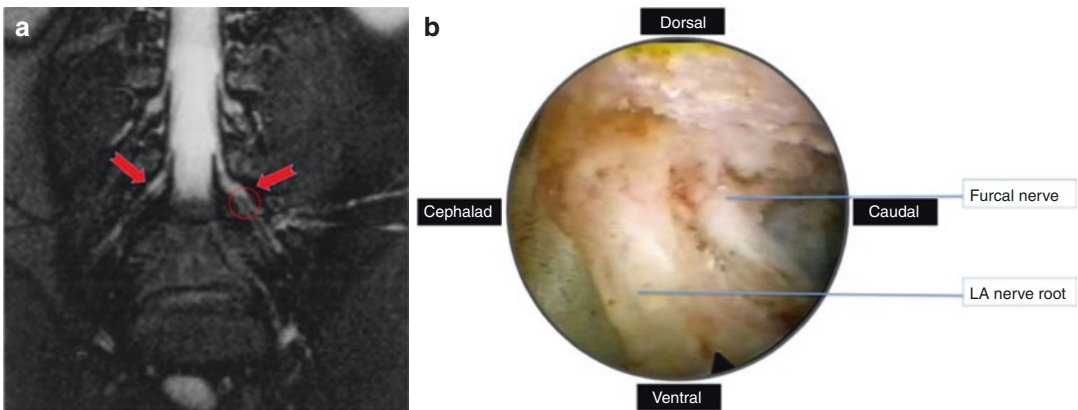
Furcal nerve. (a) Furcal nerve on preoperative MRI (red arrows); (b) endoscopic view of furcal nerve
